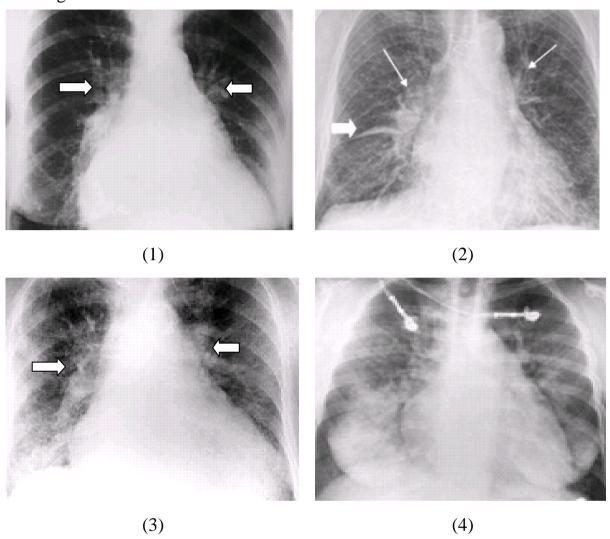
Frontal chest X-ray in congestive heart failure:
